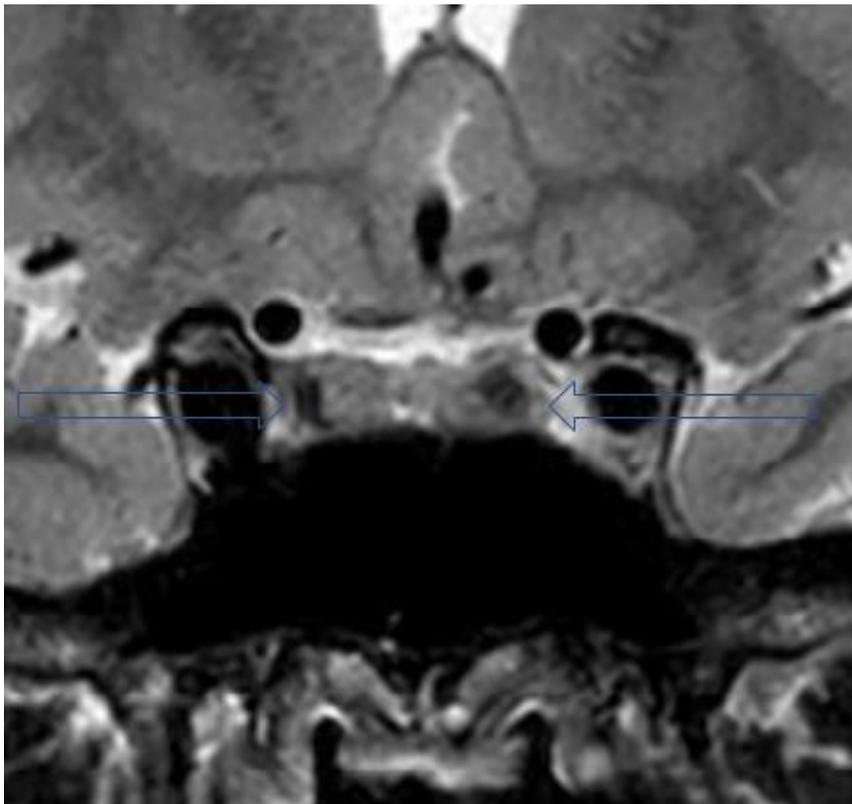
Pituitary MRI (coronal plane) shows 2 (small) pituitary adenomas (respectively 7,7 mm and 5 mm).
